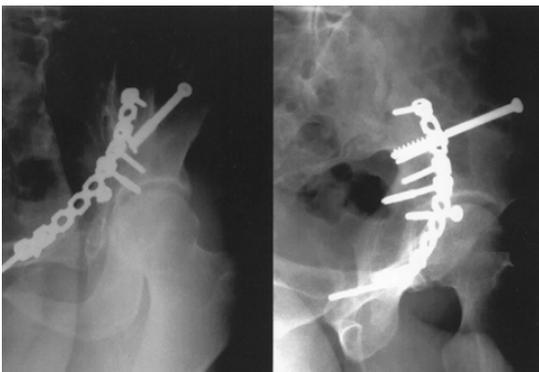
Radiographs taken 1-year after the operation showing congruous hip joint and no degenerative change.
